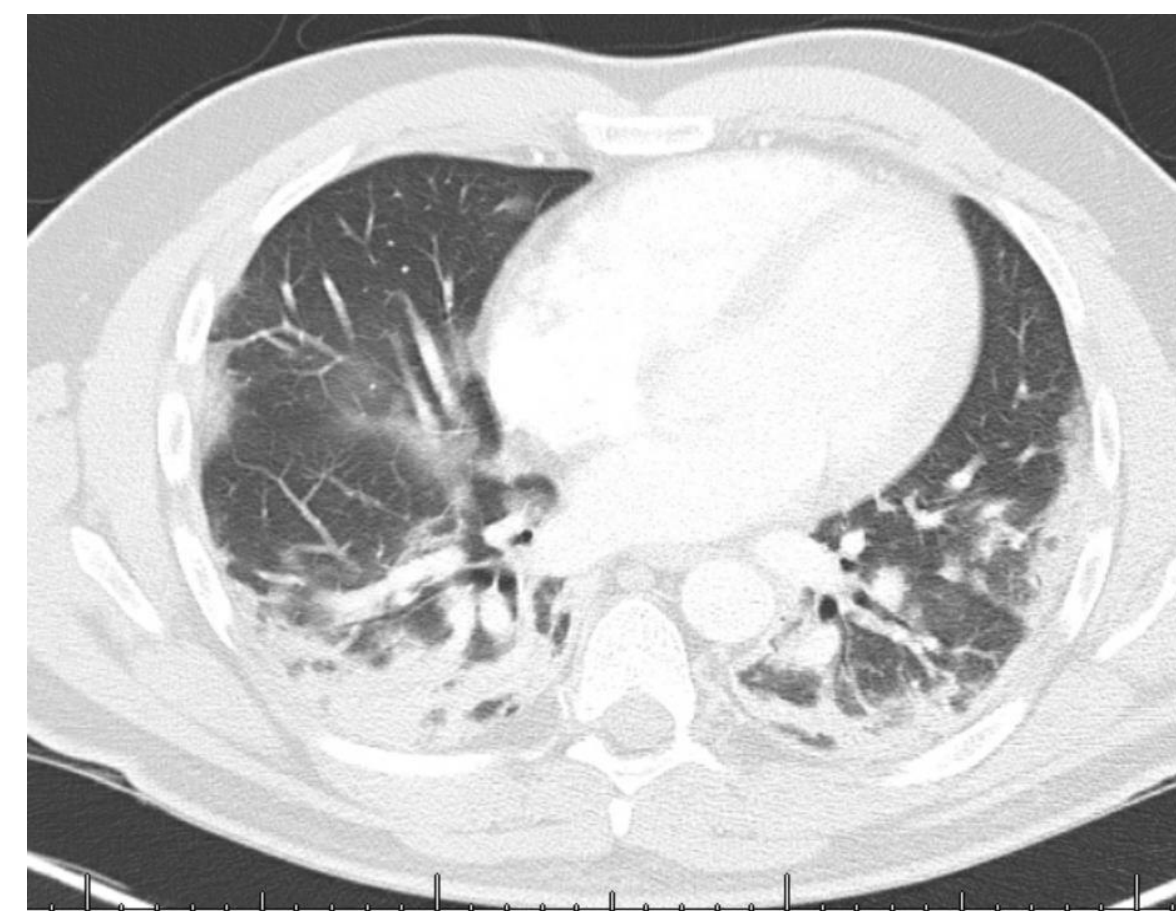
CT Chest demonstrating bilateral peripheral ground-glass opacities with dependent consolidations characteristic of COVID-19 pneumonia.
